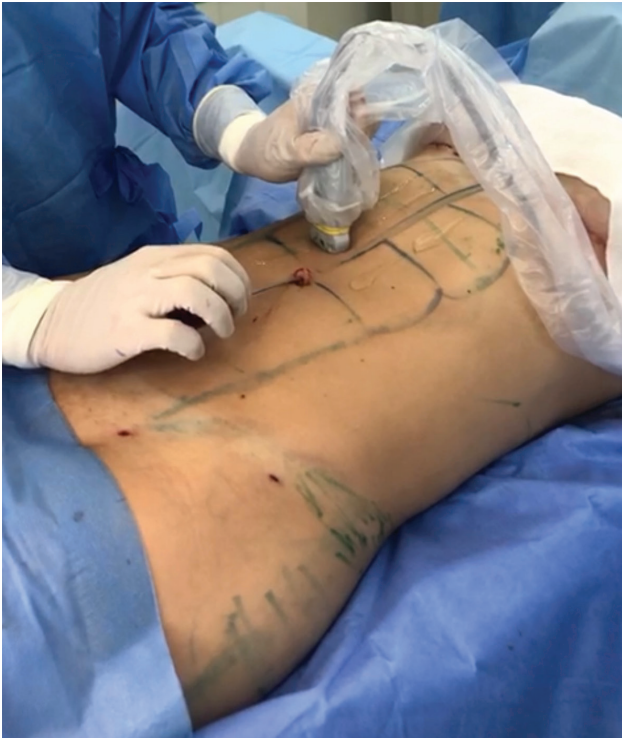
Surgeon holding an ultrasound probe with the left hand and a cannula with the right hand to perform UGRAFT. The cannula is introduced by an incision in the umbilical region and carefully guided by an ultrasound image until it penetrates the rectus abdominis sheath.
